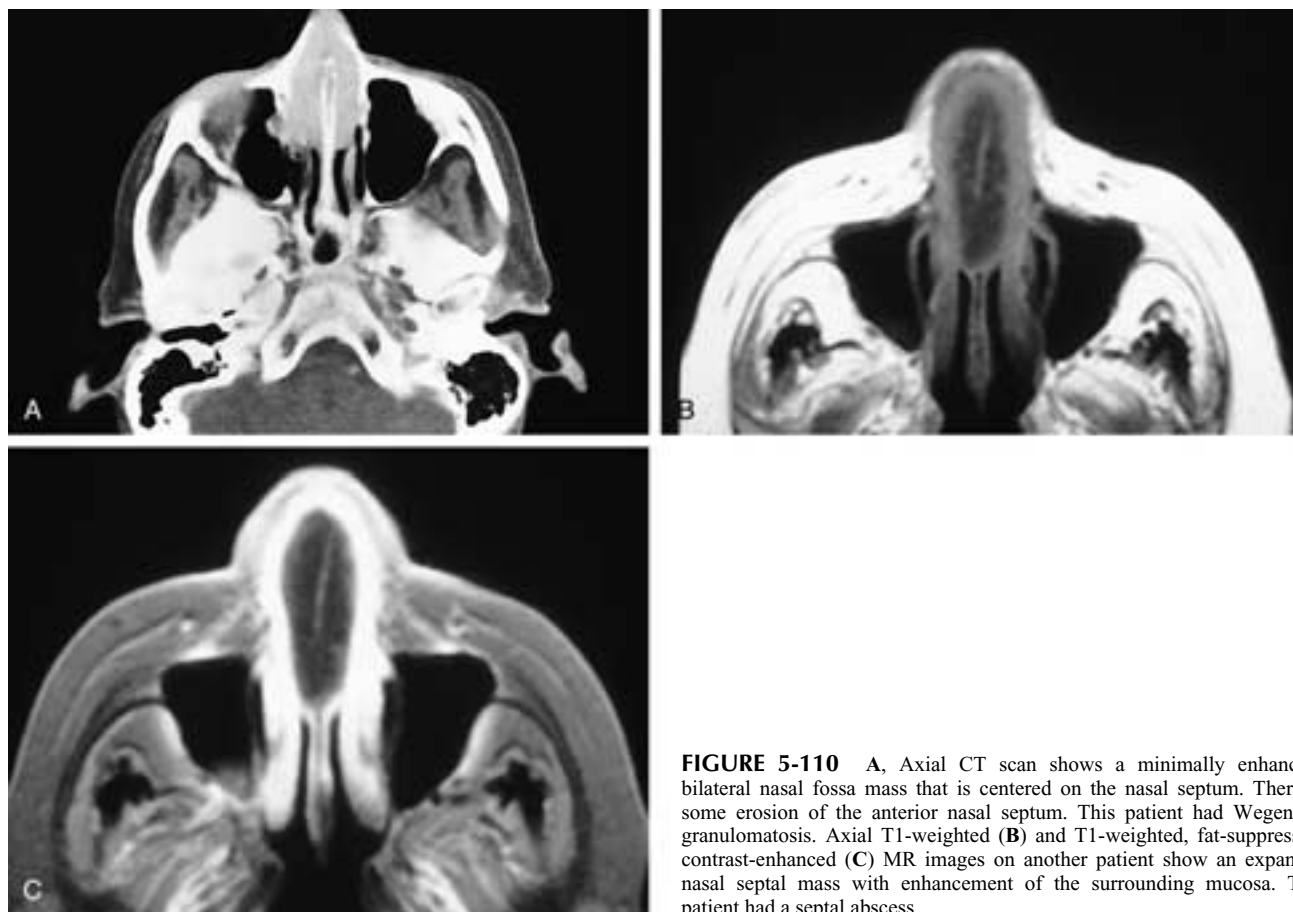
A, Axial CT scan shows a minimally enhancing bilateral nasal fossa mass that is centered on the nasal septum. There is some erosion of the anterior nasal septum. This patient had Wegener's granulomatosis. Axial T1-weighted (B) and T1-weighted, fat-suppressed, contrast-enhanced (C) MR images on another patient show an expansile nasal septal mass with enhancement of the surrounding mucosa. This patient had a septal abscess.
